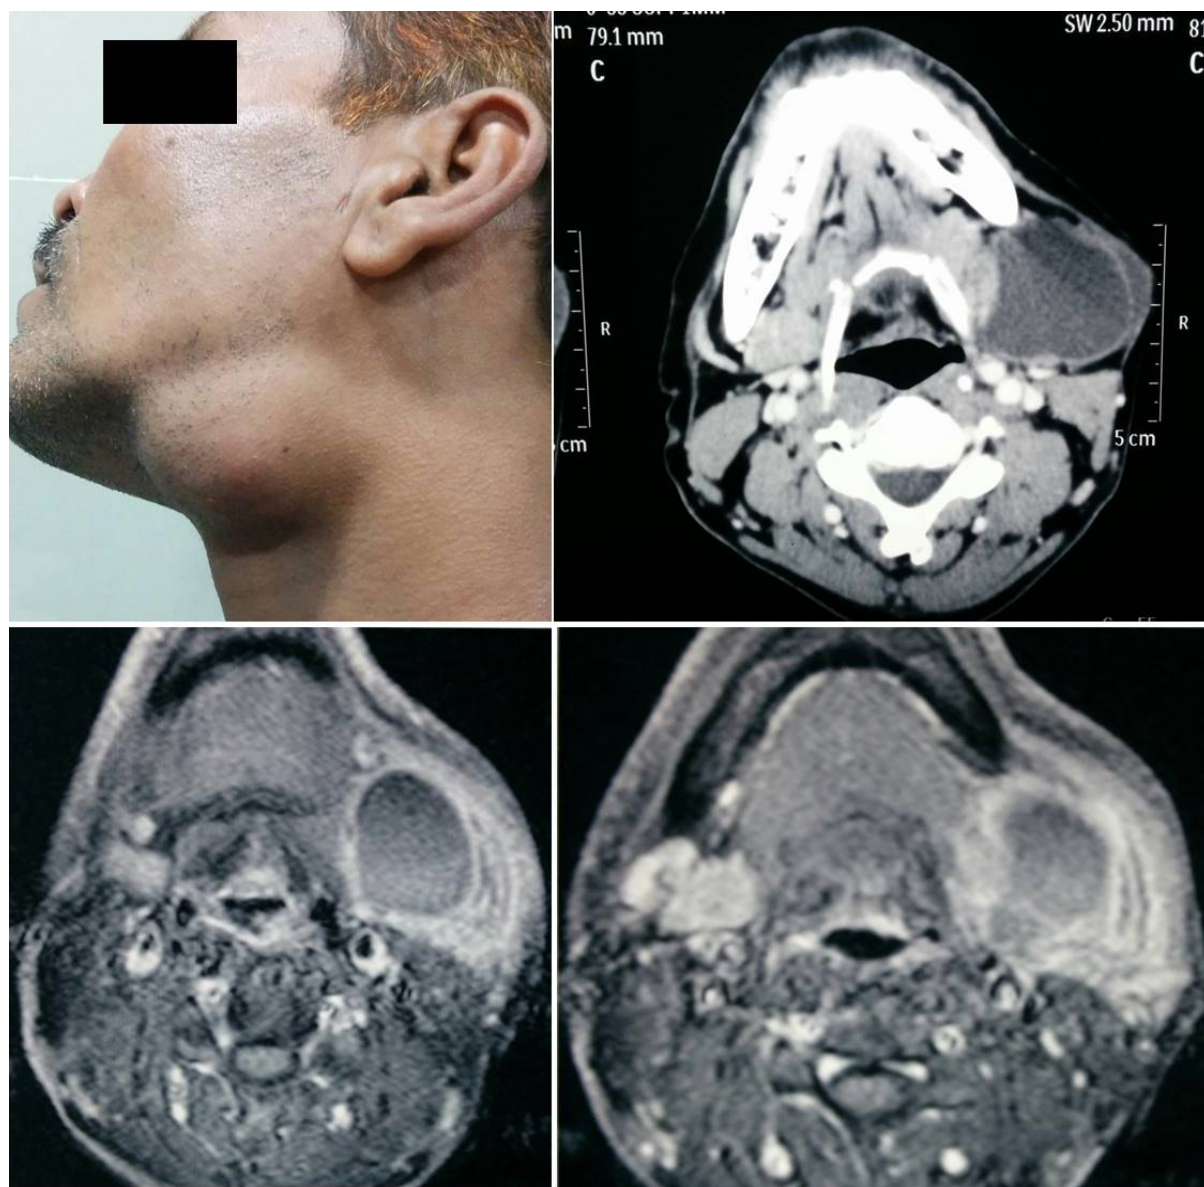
Left submandibular swelling. CT scan showing hypodense, multiloculated cystic mass lesion in the left submandibular region and abutting submandibular gland. MRI showing peripheral enhancement and was hypointense on T1W image and hyperintense on T2W image with peripheral post-contrast enhancement and obliteration of fat plane between the tumor and submandibular gland.
